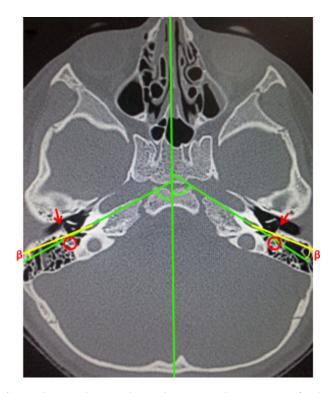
Axial computed tomography scan demonstrating the measurement of angle β , which is the angle between the line of cochlear basal turn axis and the surgical axis (yellow lines). The red circles represent the facial nerve and the red arrows show the chorda tympani.
